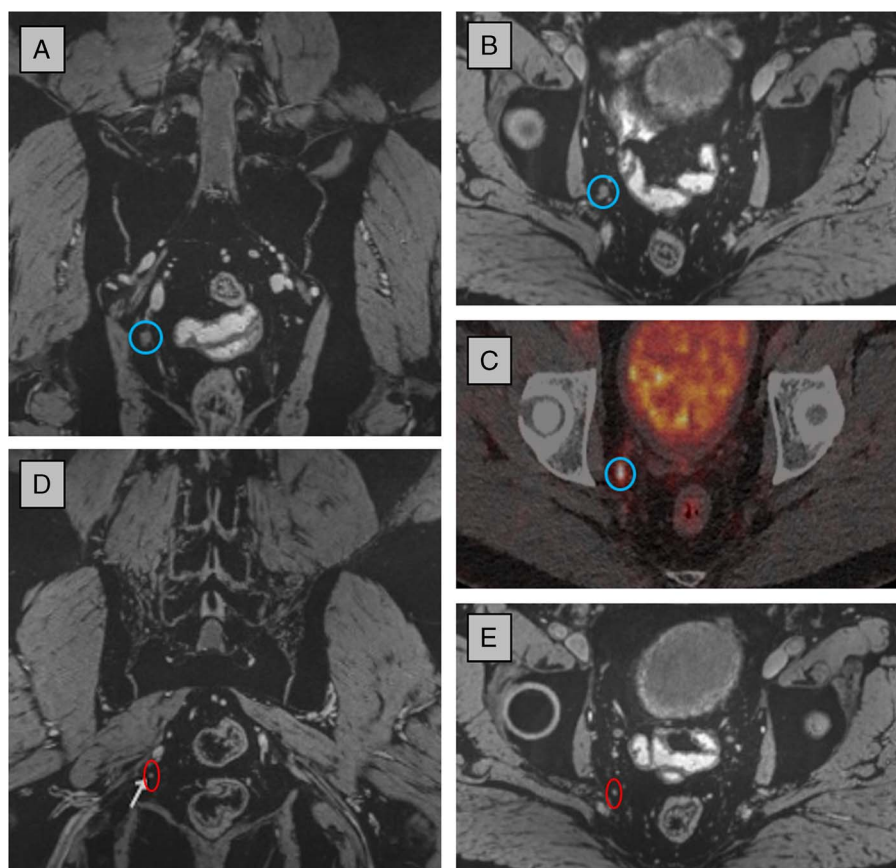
USPIO-enhanced MRI at 3 T and ⁶⁸Ga-PSMA PET-CT of a patient with recurrent prostate cancer (PSA level, 3.9 ng/mL). A large (7 mm) metastatic lymph node was visible on both modalities: blue circle in coronal (A) and axial image (B) and in fused PSMA PET-CT (C). Posterior to this node, one of multiple smaller metastatic nodes (2–3 mm) is indicated with a red circle in a coronal (D) and axial (E) view of the 3D MRI data set, which was not visible on PSMA PET-CT. Part of image and legend adapted from Fortuin et al.³² Magnetic resonance imaging parameters: 3-dimensional T2*-weighted MRI with echo time 12 milliseconds (2 combined echoes), resolution 0.85 × 0.85 × 0.85 mm, acquisition time 10 hours 10 minutes.
